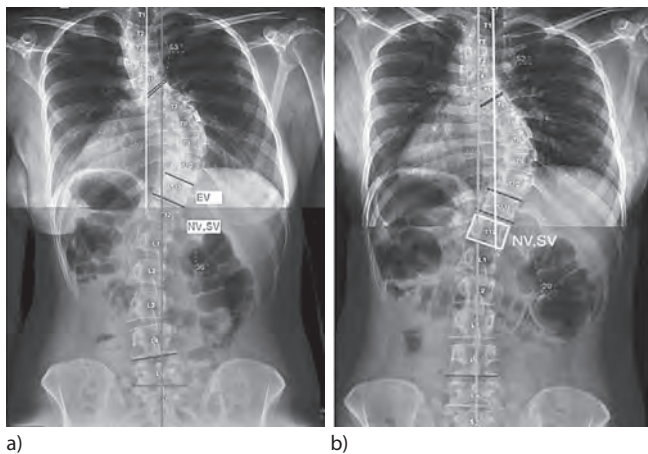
The end, stable and neutral vertebrae identified on: a) standing and b) traction radiographs
